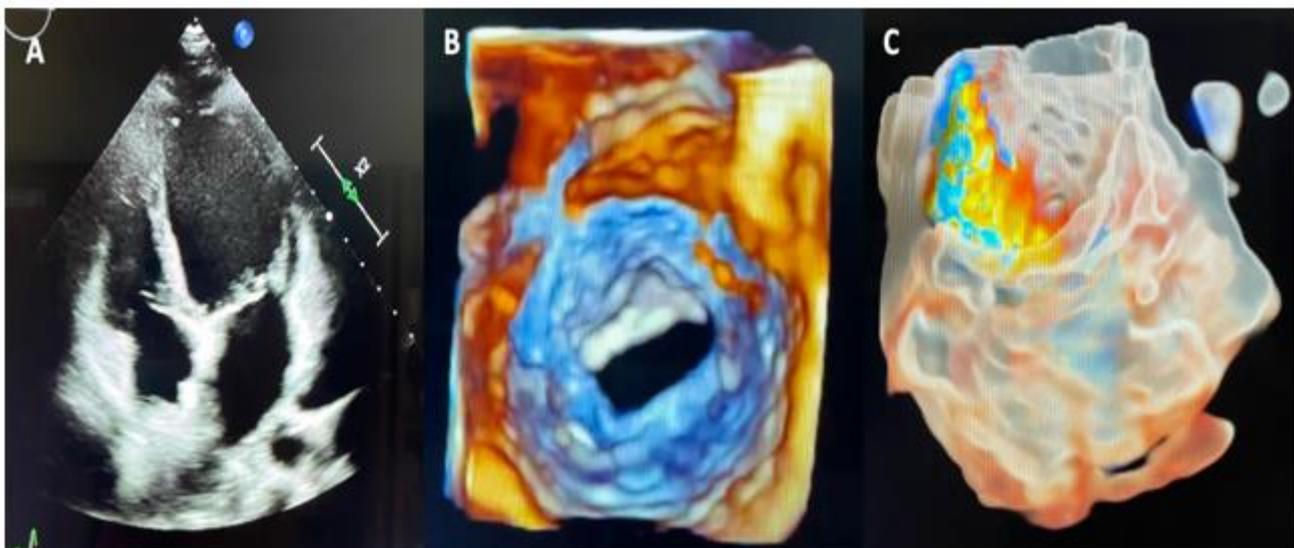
(A) Transthoracic and transesophageal echocardiogram in apical 4-chamber approach showing left atrial dilatation, LVEF of 70%. (B) Reconstruction of mitral valve area of 4.08 cm², VTI 19.9 cm and mean gradient 70 mmHg, where leaflet folding in the form of a hammock is observed. (C) Three-dimensional image showing regurgitating flow into the left atrial cavity due to moderate mitral regurgitation.
